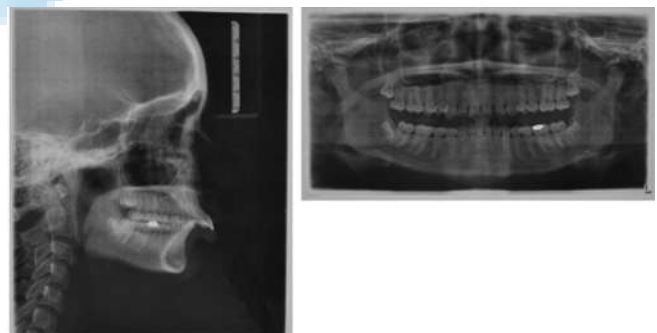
Pretreatment radiographs of case report 1
